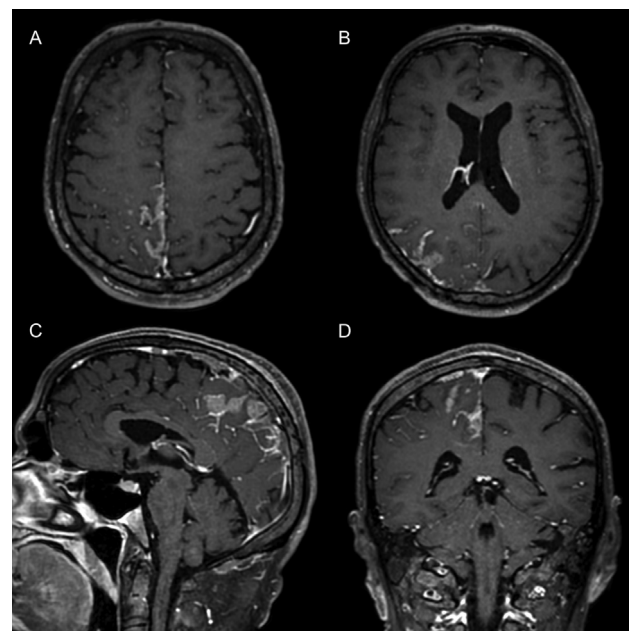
(A-B) Postgadolinium volumetric fast-spin echo black-blood T1-weighted image demonstrating thick and irregular leptomeningeal enhancement on the right frontoparietal and parietal regions. (C-D) Sagittal and coronal postcontrast vessel wall imaging respectively demonstrating a nodular lesion in the same regions.
